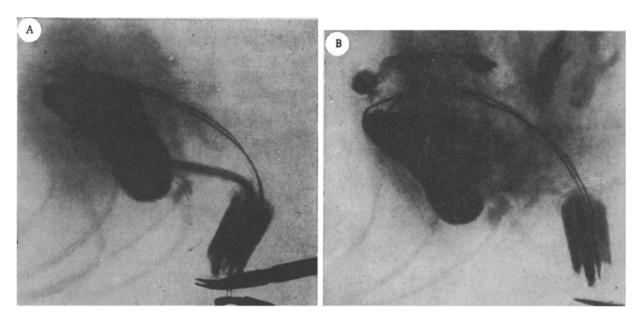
Roentgenogram of the gall bladder with the obturator in situ (A) and immediately after its removal (B). The gall bladder is filled with 40% sergosin (abrodil) solution.
